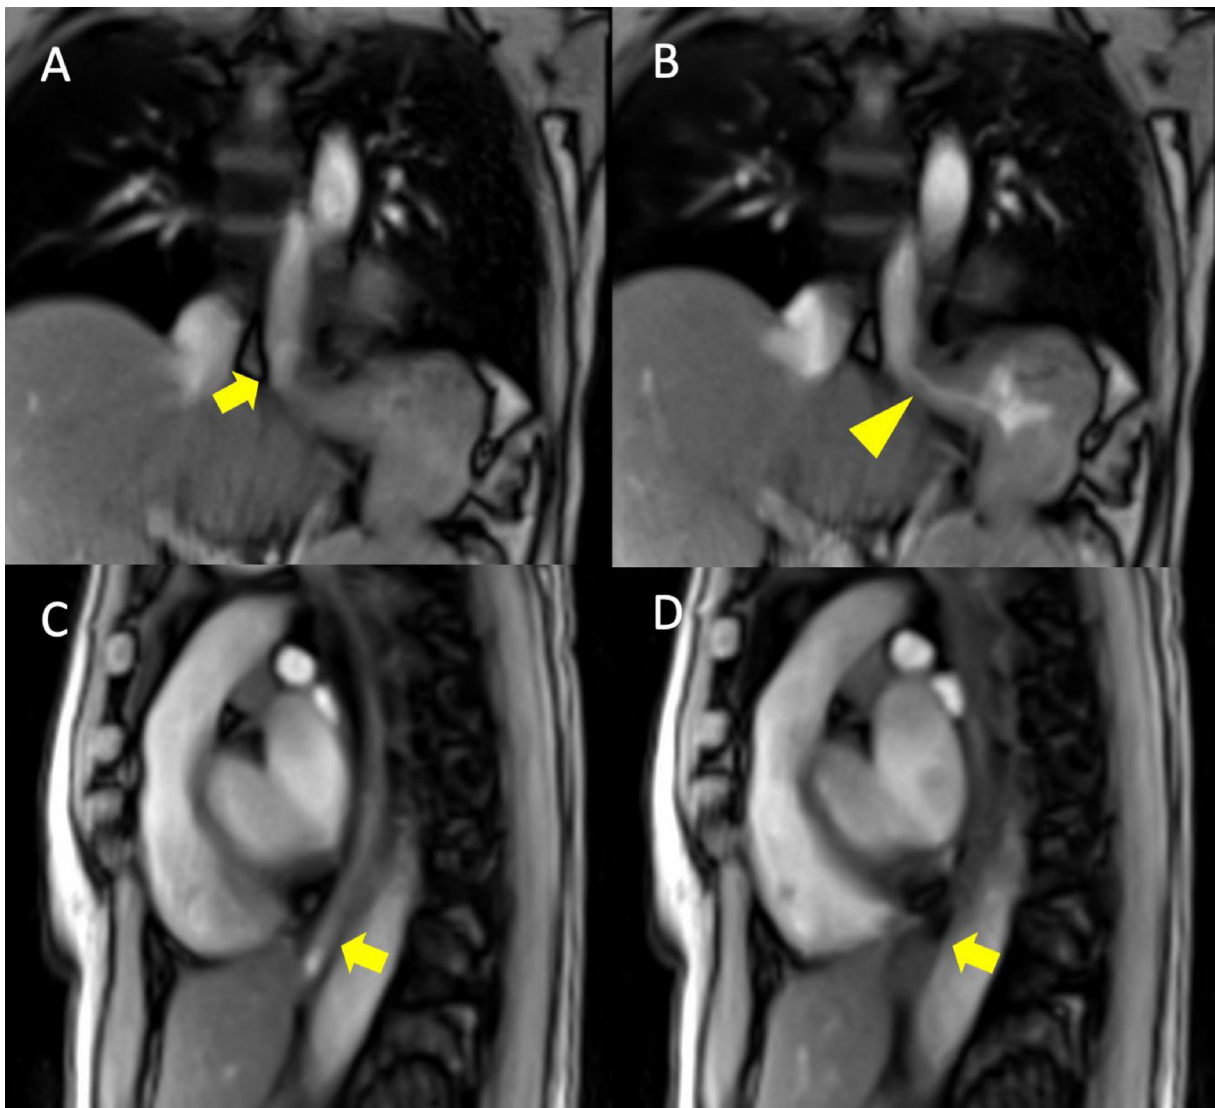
Real-time MRI of the LES during bolus passage in coronal (A, B) and sagittal planes (C, D). (A and B) As the bolus enters the distal esophagus (arrow), it passes through the gastroesophageal junction (arrow head). (C and D) The same observation can be made on the sagittal planes. Bolus enters the distal esophagus (arrow) and is cleared after several propulsive contractions. Also see supplemental Video 1.
